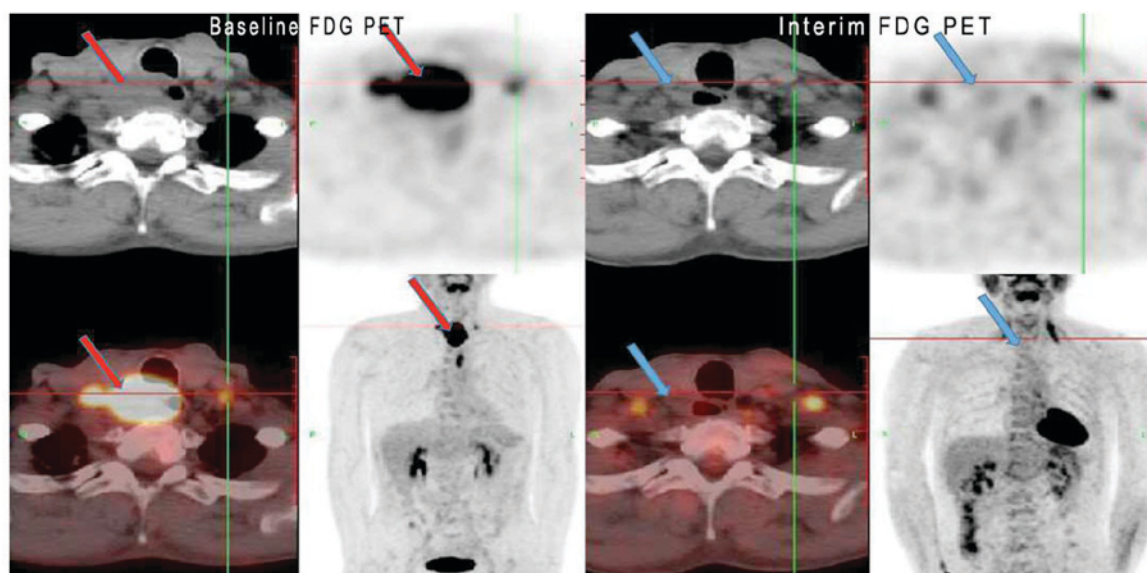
^{18}F -FDG PET scan of a 58-year-old male with cervical esophageal squamous cell carcinoma. The red arrow indicates the primary tumor at baseline ^{18}F -FDG PET scan, the maximum standardized uptake value was 21.2 and the metabolic tumor volume was 36.8 cm^3 . The blue arrow indicates the primary tumor after 40 Gy/4 weeks of starting radiation therapy, tumor FDG uptake had ceased with a final tumor complete response. ^{18}F -FDG PET, ^{18}F -fluorodeoxyglucose positron emission tomography.
